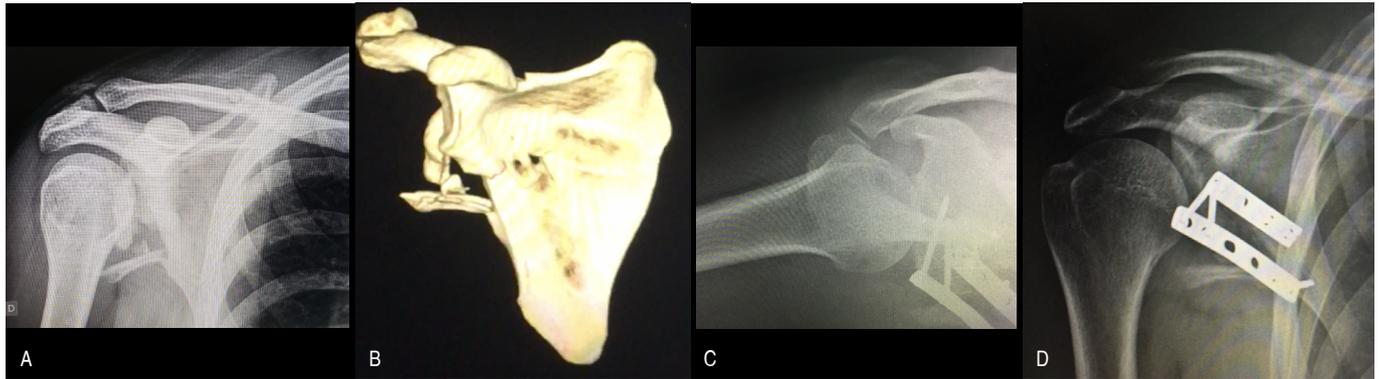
A: Anteroposterior (AP) radiograph of a 33-year-old patient with AO type 14F1.2 fracture; B: Computed tomography scan with 3D reconstruction; C and D: Postoperative AP and axillary radiographs, respectively, of a patient subjected to fixation of small fragments with two dynamic compression plates (DCP).
